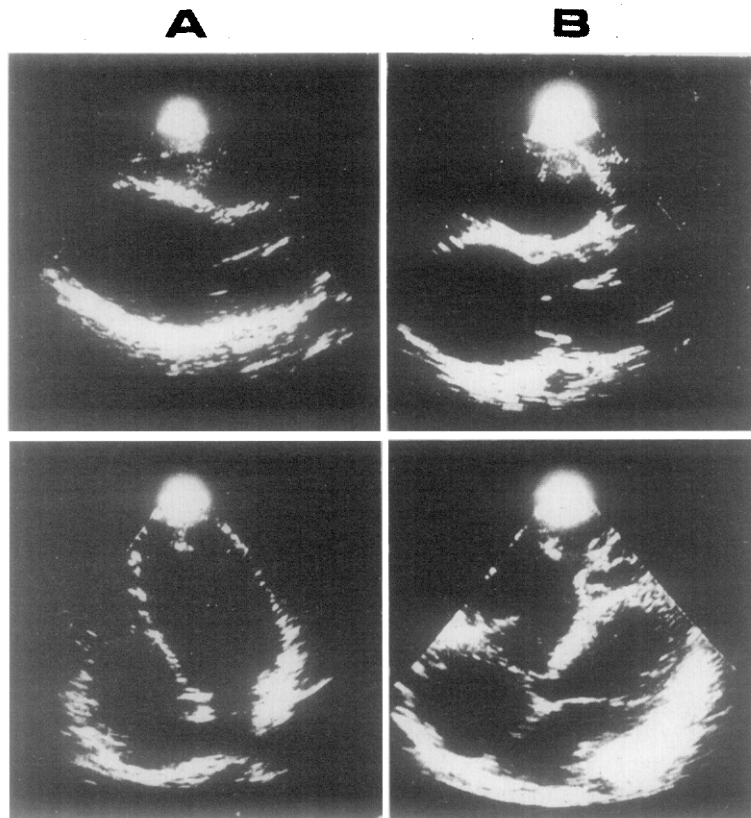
Cross-sectional echocardiograms. *Top*, Long-axis view. *Bottom*, Apical four-chamber view. *A*, Nineteen-year-old boy with IDC (propositus). *B*, His 23-year-old brother with right ventricular dysplasia; note particular involvement of infundibulum and apex of right ventricle.
